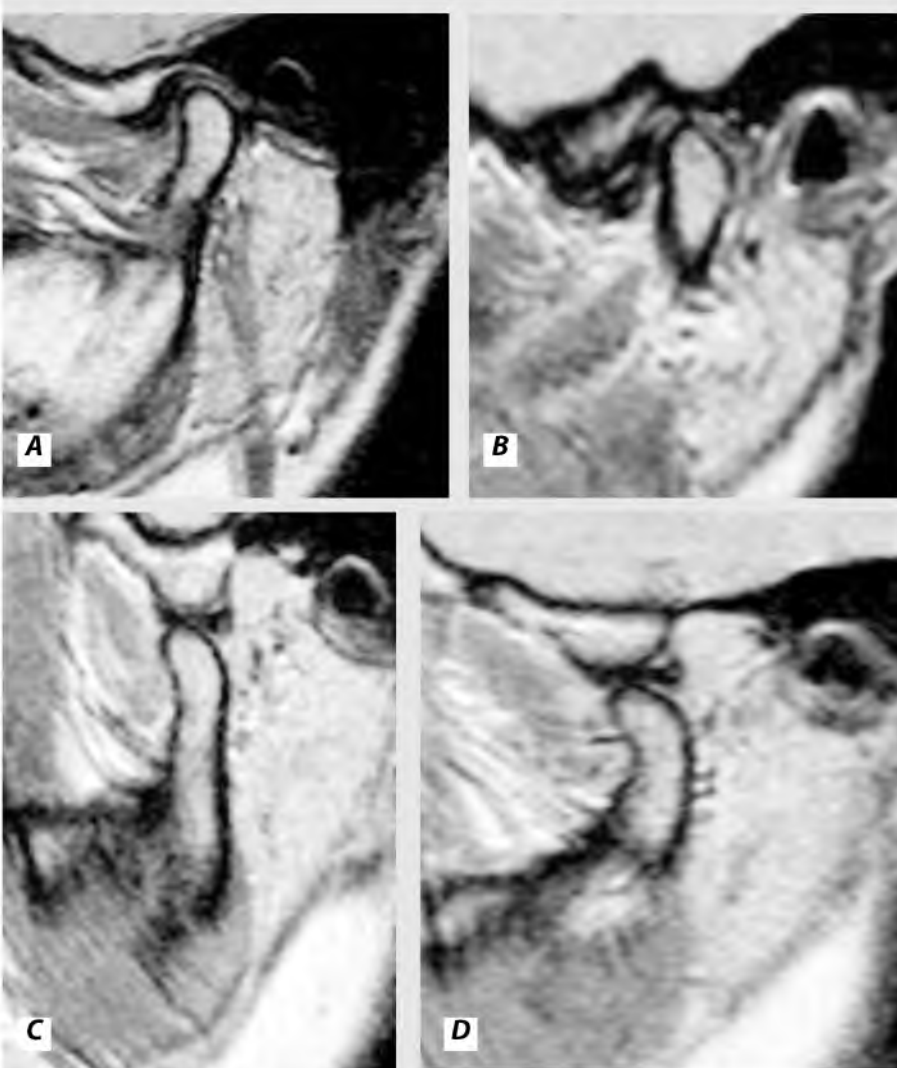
MR Imaging of the TMJ before treatment: (A) A closed-mouth sagittal T1-weighted image shows a normal relationship of the mandibular condyle, the disk at the 11 o'clock position, the temporal fossa and the articular eminence; (B) Closed-mouth sagittal T1-weighted image shows the anteriorly displaced disk; (C, D) Open-mouth sagittal T1-weighted images shows the normal position of the disk between the mandibular condyle and articular eminence
